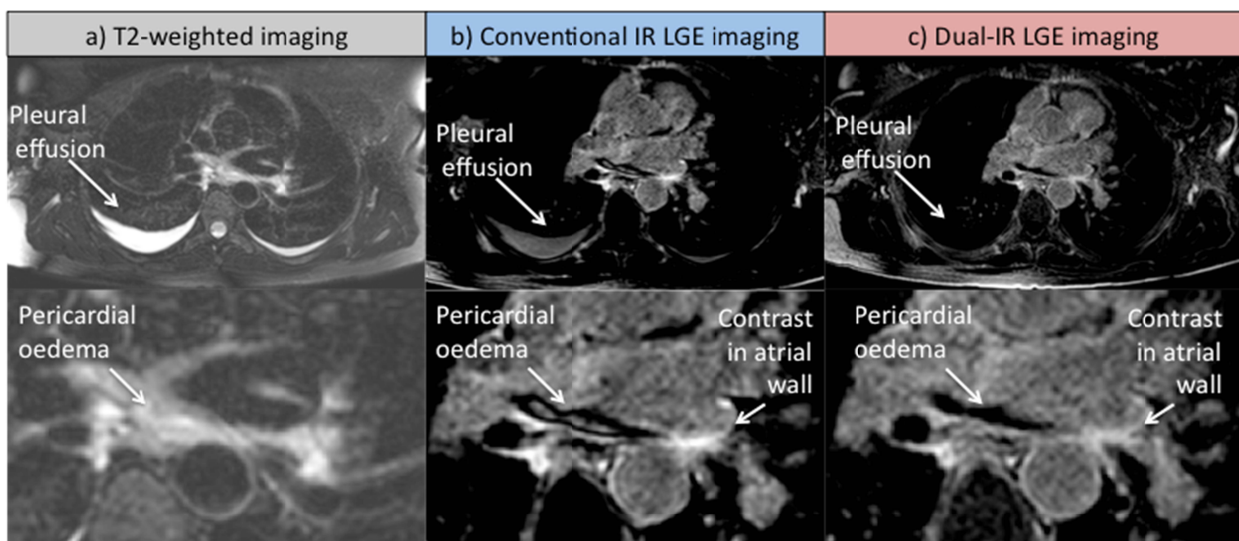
T2-weighted oedema imaging (a) showing bright signal in the pleural effusion and pericardial oedema, conventional IR-GE LGE imaging (b) showing high signal in the pleural effusion, pericardial oedema and contrast in the atrial wall and dual-IR LGE imaging (c) which suppresses the signal in the pleural effusion and pericardial oedema but maintains high signal in the atrial wall.
